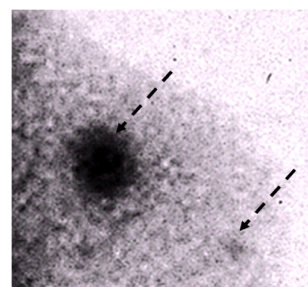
Mamo-scintigramme with ^{99m}Tc MIBI, confirmation of the anterior presumption
